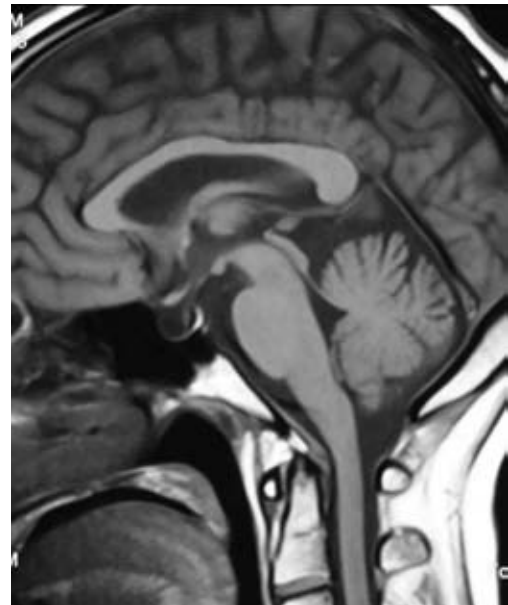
MRI pituitary sagittal view showing pituitary fossa filled with cerebrospinal fluid and stalk touching the base of pituitary floor; features suggestive of empty sella.
